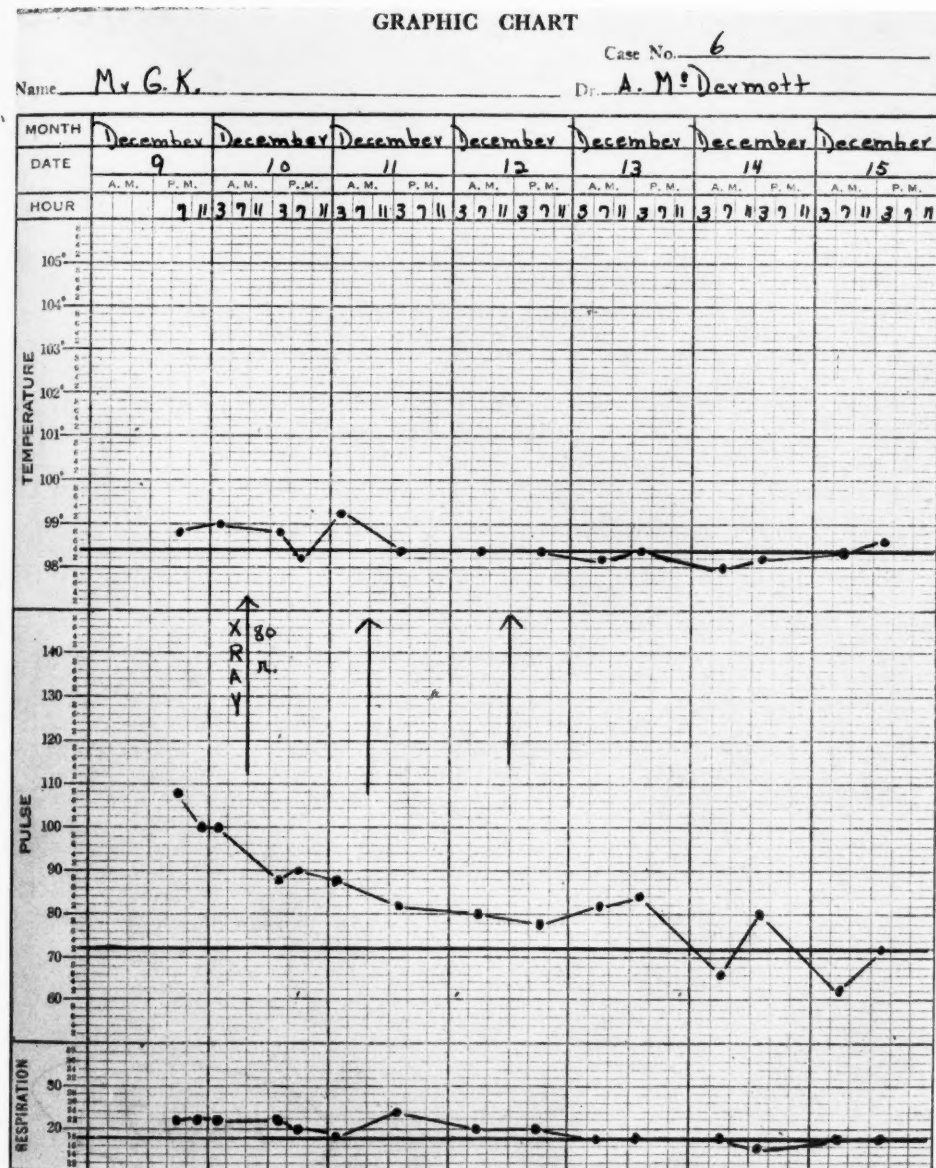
Case 6. Diagnosis: compound fracture of the right tibia. X-ray technic: kv. 110; ma. 5; distance 50 cm.; filter 3 mm. Al; r units, 80 per treatment, total 240; port, right leg anteriorly only; result, excellent.
